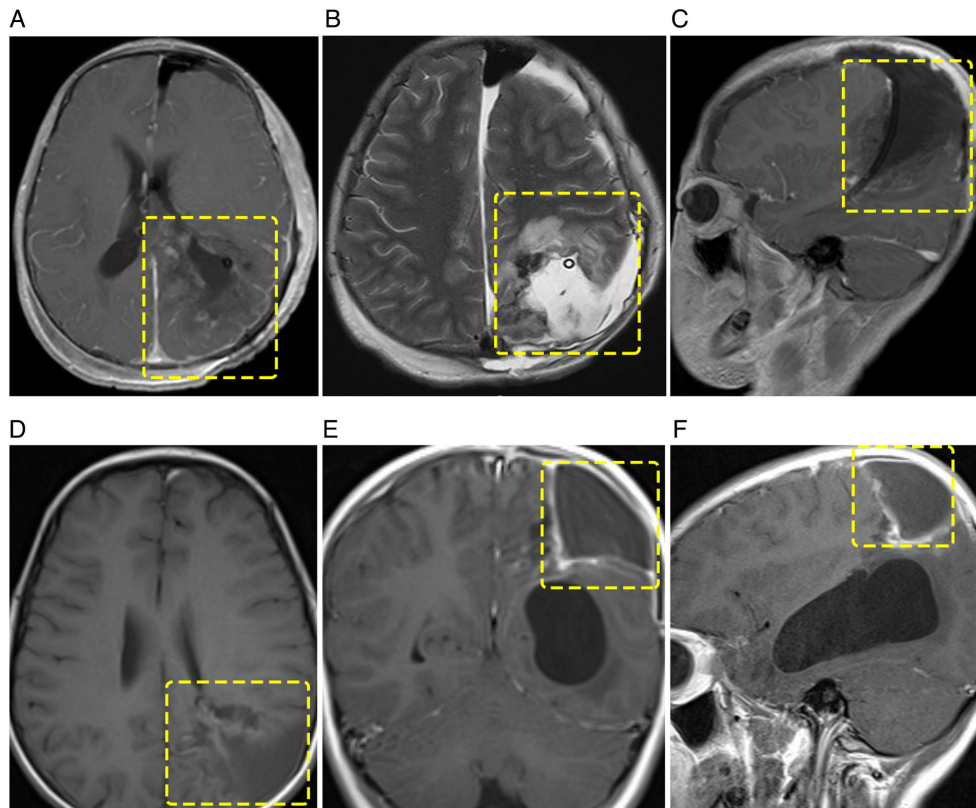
Cranial MRI images at 3 days and 3 months post-surgery. (A) Axial T1-weighted image without contrast. (B) Axial T2-weighted image. (C) Sagittal T1-weighted image. MRI performed 3 days post-operation showed complete tumor resection, with notable improvement in brain sulci and ventricular compression compared with preoperative imaging. The midline had largely returned to normal, with some residual fluid collection in the surgical area and partial brain tissue expansion. (D) Axial T1-weighted image. (E) Coronal T1-weighted image. (F) Sagittal T1-weighted image. Postoperative MRI at 3 months showed no signs of tumor recurrence. Edema in the surgical area gradually subsided, and ventricular expansion was noted. The yellow dashed box indicates the surgical region.
